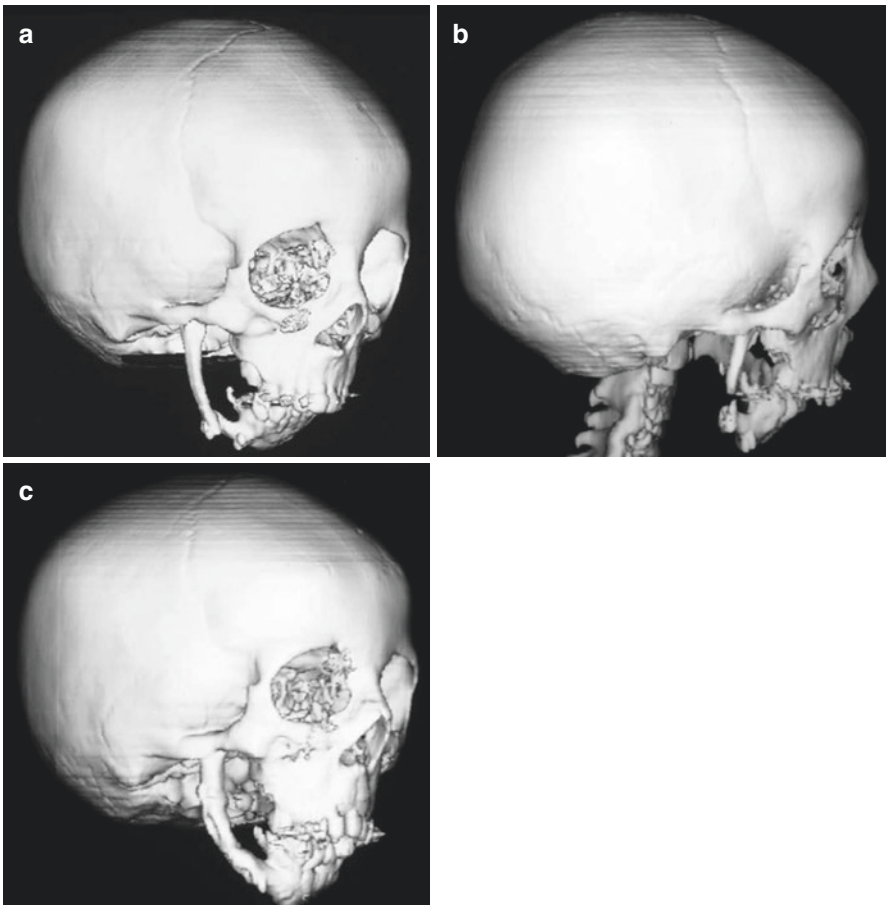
Serial CT scans. (a) Following reconstruction of the ramus/body of the mandible with an autogenous rib graft. (b) Following distraction (osteotomy in the rib graft) with development of fibrous union. (c) Following successful secondary distraction of a larger iliac bone graft reconstruction of the mandibular defect
